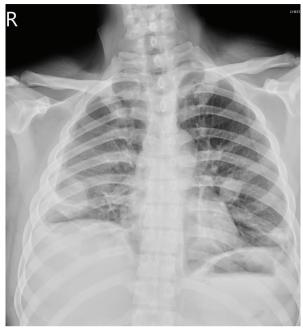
Chest X-ray showed bilateral consolidations and right pleural effusion.
